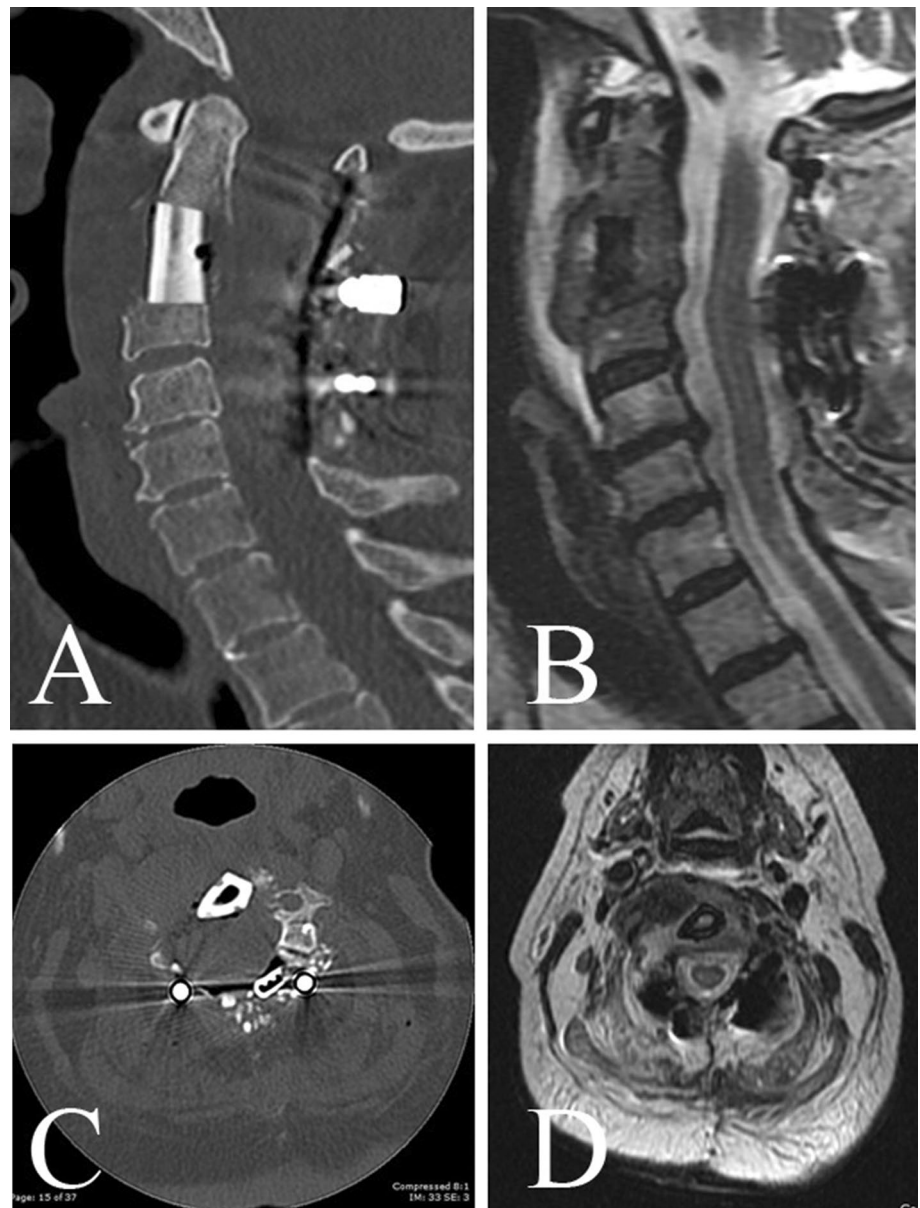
Postoperative computed tomography in sagittal (a) and axial (c) cross sections as well as magnetic resonance imaging in sagittal (b) and axial (d) cross sections showing appropriate graft placement as well as circumferential spinal cord decompression, respectively
